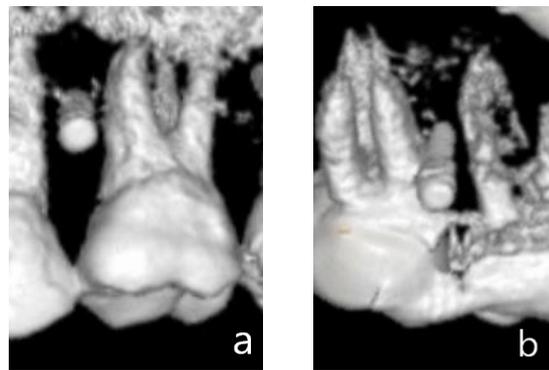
The relative positions of miniscrews and roots on CBCT images taken after miniscrew insertion.: a, miniscrews well-placed between roots; b, placement of miniscrews causing damage to roots
